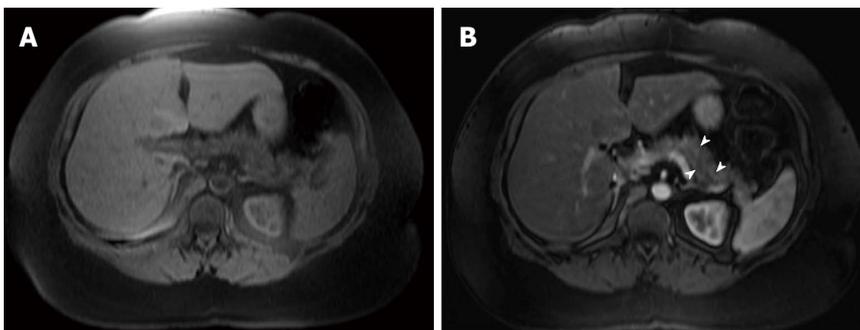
Necrotizing pancreatitis. A: Axial T1-weighted fast low-angle shot (FLASH) image with fat-suppression; B: Axial post-Gadolinium 3D-GRE T1-weighted image with fat-suppression during the hepatic arterial-dominant phase. The pancreas shows diffuse decreased T1 signal intensity (A) with patchy areas of minimal enhancement (arrowheads) (B) in keeping with necrotizing pancreatitis.
